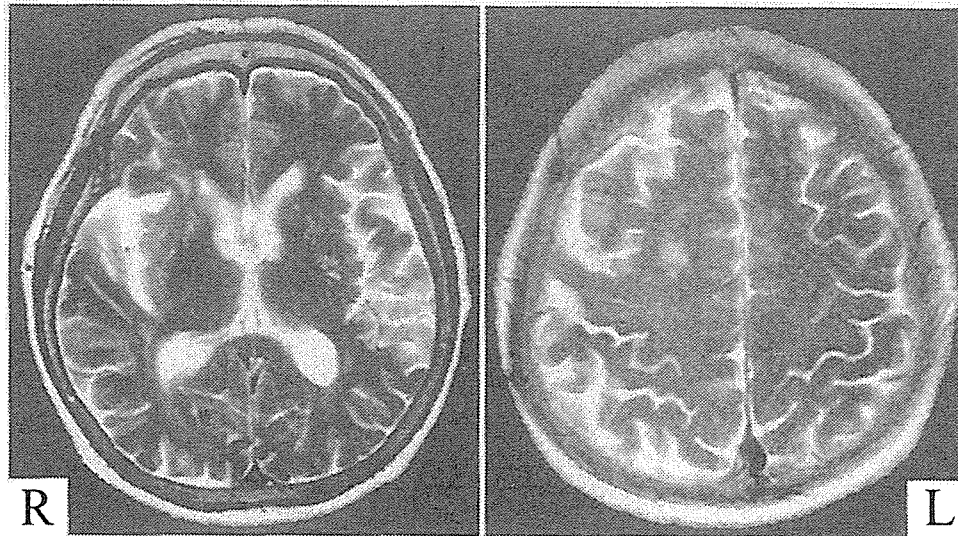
Case 2. Axial T<sub>2</sub>-weighted MR images obtained at admission, showing small areas of high signal intensity in the right white matter in the frontal lobe and bilateral basal ganglia.
